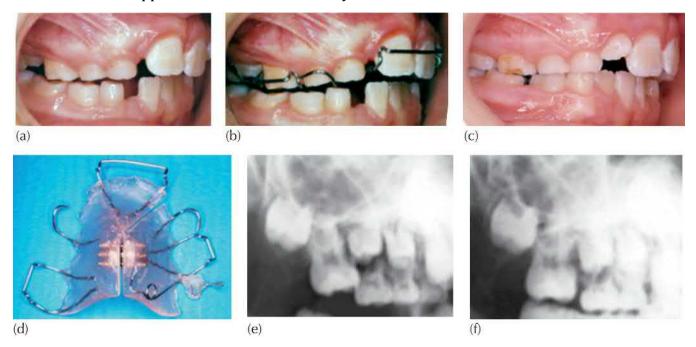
(a) Incomplete eruption of the maxillary first permanent molar, due to abnormal angulation of its long axis. It has become impacted beneath the distal edge of the deciduous second molar crown. (b) A removable acrylic plate in place, with a distally activated finger spring for the molar. (c) The completed treatment with the molar uprighted and in occlusion. (d) The removable appliance comprises five retention clasps and a palatal 'finger' spring that crosses the occlusal surface of the mesially tipped and partially erupted first molar. (e, f) Lateral jaw radiographs before and after treatment.
